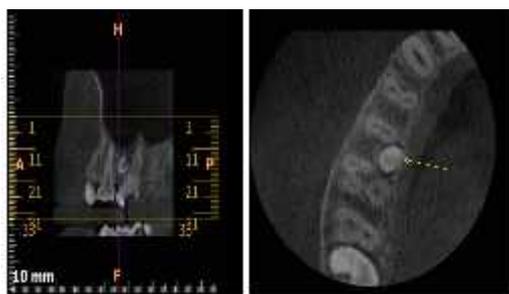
CBCT Axial view revealing presence of unerupted incompletely formed supernumerary tooth present between 15 and palatal root of 16.
